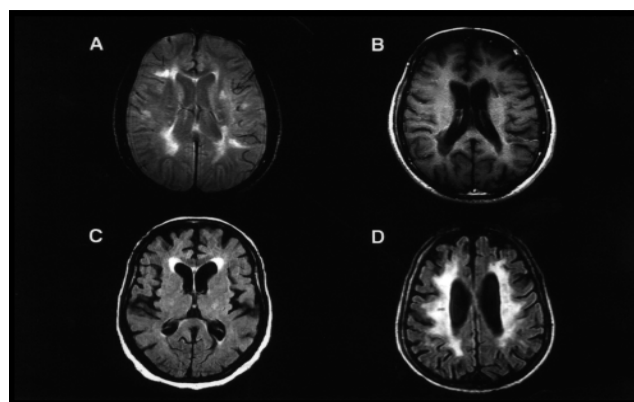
Patient 2 - A & B - MRI of the brain with and without gadolinium. Both T1 and T2 sequences reveal numerous white matter lesions with sharp margins, primarily located periventricularly with some seen in cortical white matter. Following intravenous administration of gadolinium (B), no significant enhancement was seen in any of the white matter lesions. Patient 3 - C - MRI of brain, FLAIR sequence, shows generalised moderate atrophy with evidence of periventricular white matter disease, most pronounced in the frontal lobe area. Patient 5 - D - MRI of the brain, FLAIR sequence shows a bilateral hyperintensity combined with brief, interventricular white matter that appears to be confluent.
